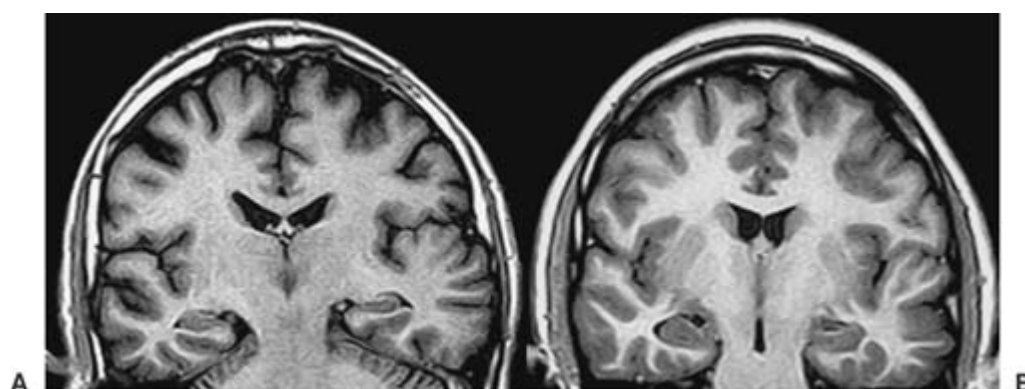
T1-IR coronal images from two patients with *LGI-1* mutation, showing left temporal lobe malformation, with a dysgenetic aspect of temporal gyri and enlargement of the lateral aspect of the temporal lobe. (Reproduced with permission, from Kobayashi E, Santos NF, Torres FR, et al. Magnetic resonance imaging abnormalities in familial temporal lobe epilepsy with auditory auras. *Arch Neurol.* 2003;60(11):1546-1551. Copyright © 2002, American Medical Association. All rights reserved.)
